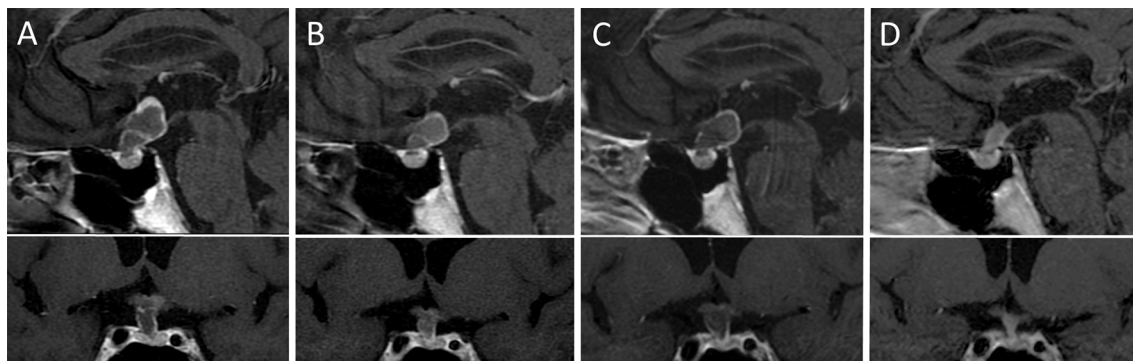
Gadolinium-enhanced sagittal (upper) and coronal (lower) T1 MRI before (A) and at 1 month (B) and 3 months (C) after starting initial corticosteroid therapy. Homogeneously enhanced pituitary gland, enlarged stalk and cystic suprasellar mass with enhanced wall thickness seen before treatment show some resolution 1 month after starting treatment but recurrence at 3 months. Six months after starting combination therapy with corticosteroid and mycophenolate mofetil, the pituitary stalk and suprasellar mass are markedly reduced in size (D).
